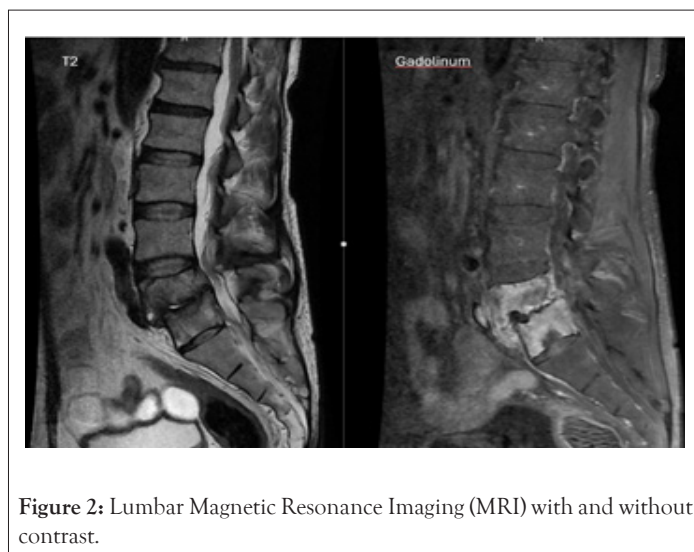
Lumbar Magnetic Resonance Imaging (MRI) with and without contrast.
